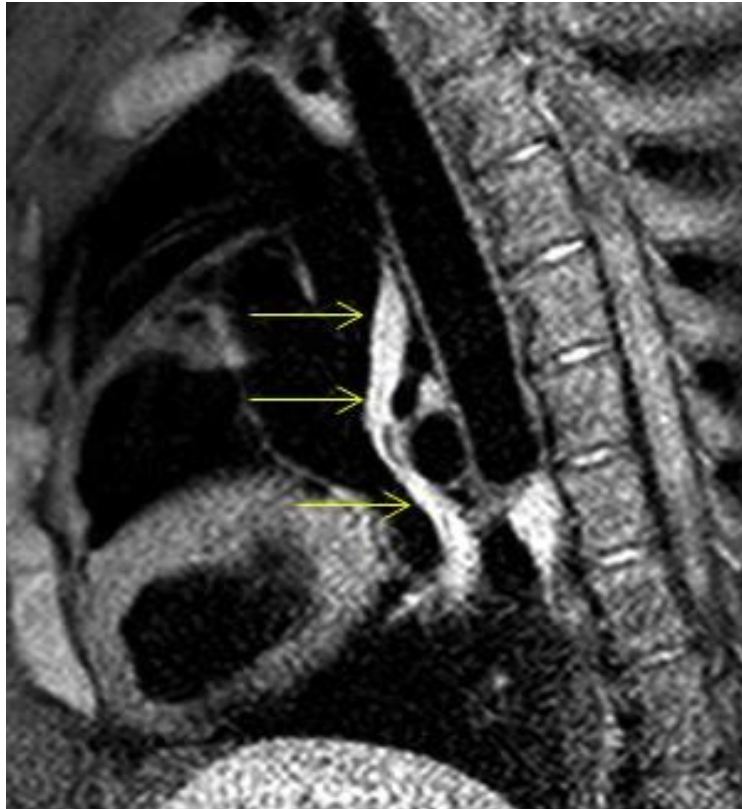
Sagittal T2W MR image following intercaval ablation demonstrating enhancement along the ablation line (arrows).*
